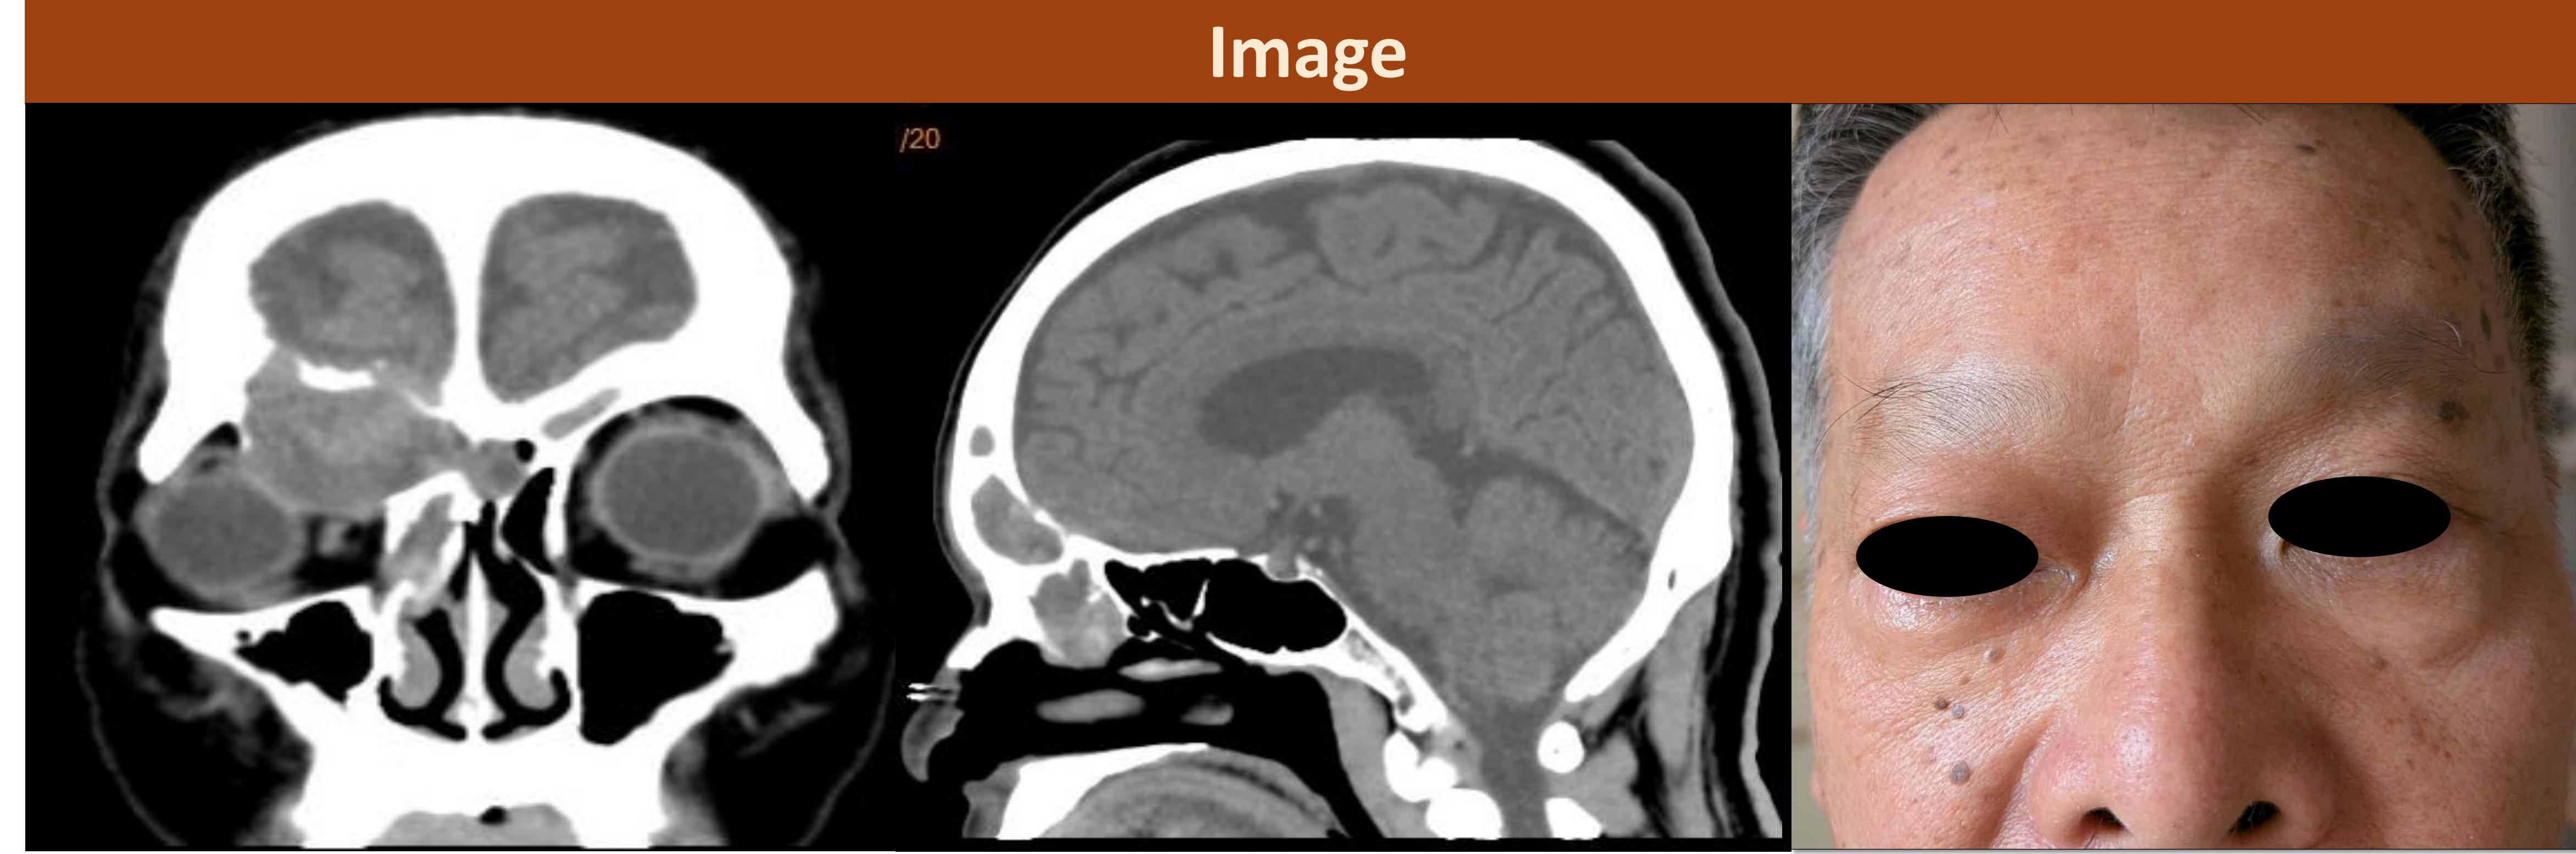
Sinus CT (-) showed Severe frontal sinusitis with inferior protrusion in the right orbital cavity; (A) Coronal View (B) Sagittal view (C) Assymmetric facial expression, exophthalmos and hypotropia of right eyes was noted (pre operation)
